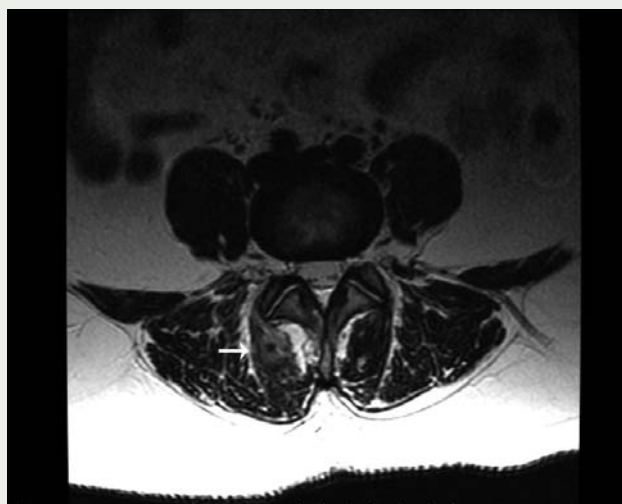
Axial MRI image of L4-5 reveals paraspinous edema (arrow).
